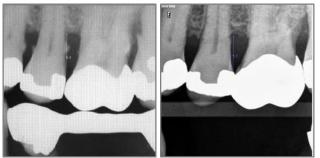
Bone regeneration observed on radiographic images of patient #7 before (left image) and 4 years following TwinLight® treatment (right image). Source: Baltimore Center for Laser Dentistry.
